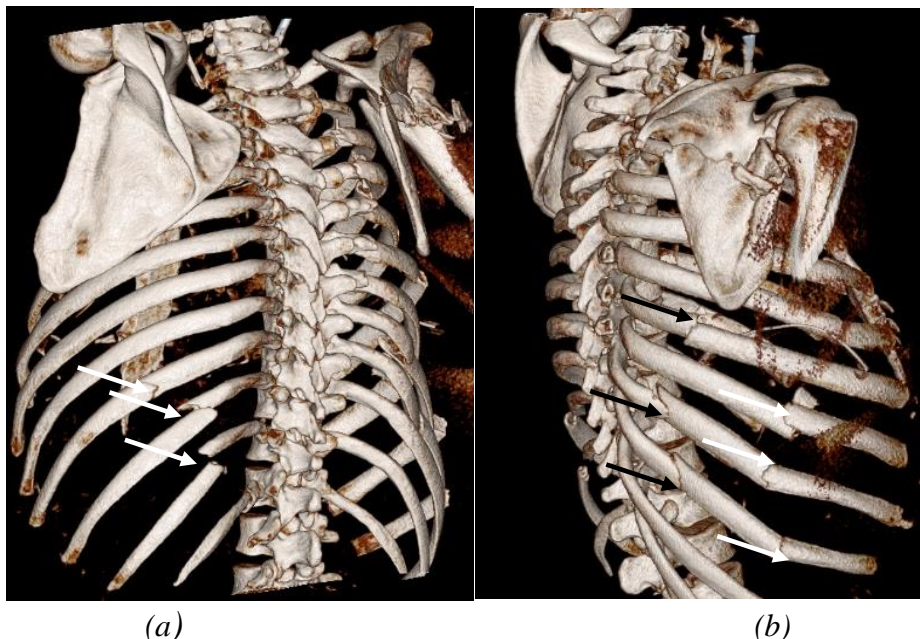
Three-dimensional CT image obtained from the same patient .(a) shows fractures of three contiguous ribs in the right side .(b) shows multiple displaced fractures of three contiguous ribs in the left side . Each rib has both a posterolateral fracture (white arrows) and a posterior fracture (black arrows), which together produce a flail segment.
